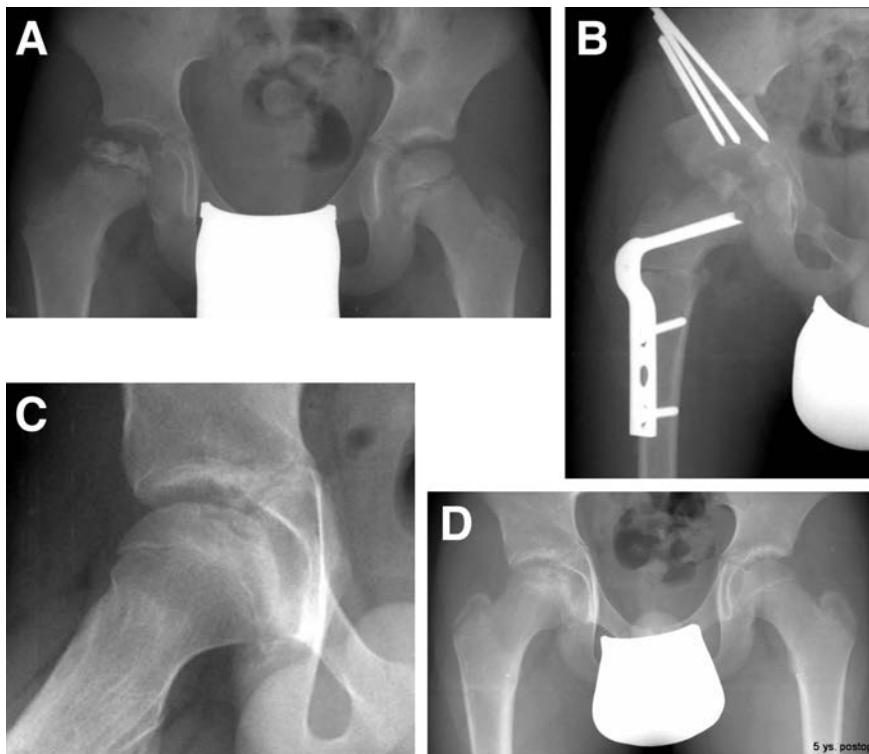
A 7-year-old boy with severe Legg-Calvé-Perthes disease and loss of containment (A); (B) X-ray after containment improving surgery with triple and varus/rotation femoral osteotomy; (C,D) 5 ys. postoperatively.
